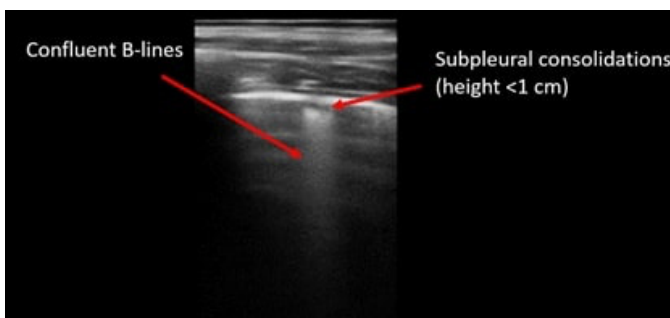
Abnormal lung ultrasound image (score 2) with confluent B-lines, and subpleural consolidations (height <1 cm)
